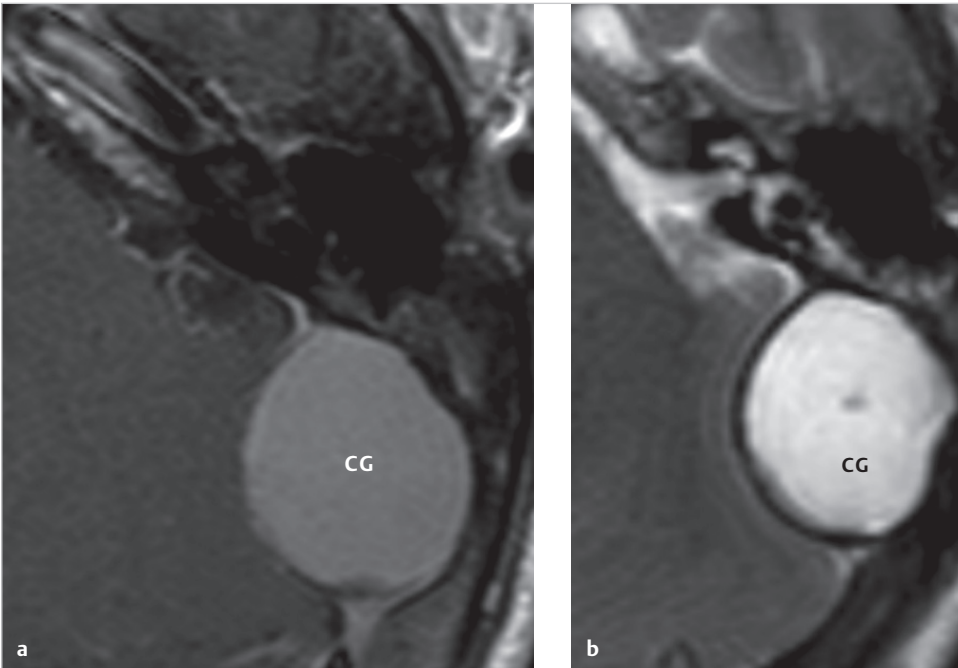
Further radiologic examination using MRI showed large round-shaped mass beneath the mastoid, pushing the posterior fossa dura to compress the cerebellum. The lesion shows high signal in T1 (*a*), and very high in T2 (*b*) corresponding to cholesterol granuloma. CG, cholesterol granuloma.
